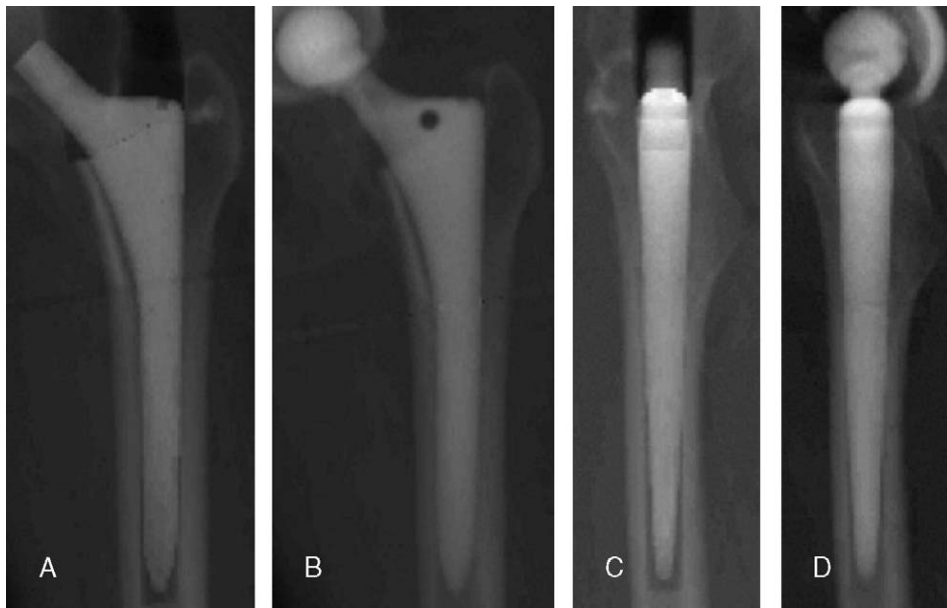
A 47-year-old woman with degenerative arthritis underwent THA using the ROBODOC system. A, Anteroposterior synthetic radiograph from preoperative planning. B, Anteroposterior synthetic radiograph reconstructed from postoperative CT data. C, Lateral synthetic radiograph from preoperative planning. D, Lateral synthetic radiograph reconstructed from postoperative CT data.
